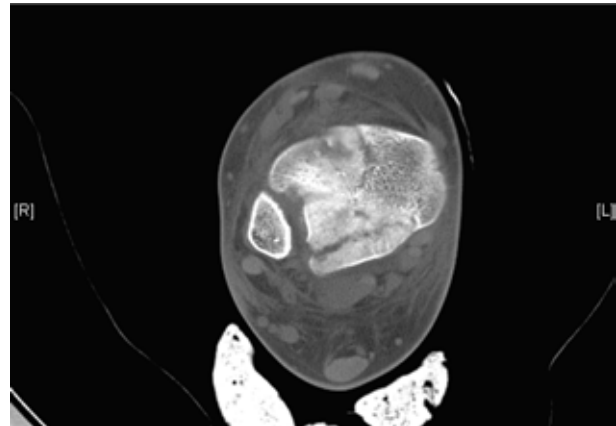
CT axial view revealing detailed configuration of a three-fragment triplane fracture.
